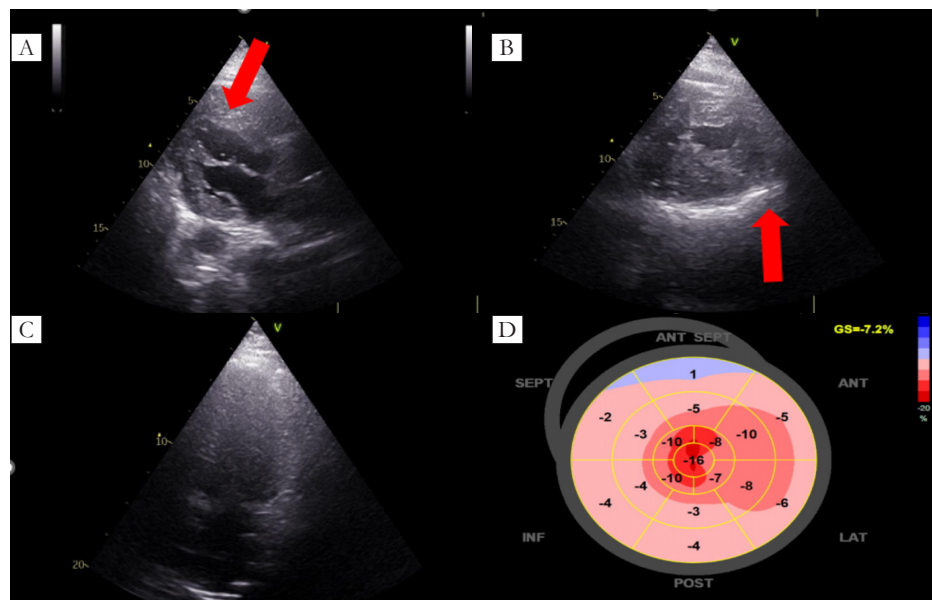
(a) PLAX echocardiography view shows increased myocardial thickness. (b) SAX view shows increased myocardial thickness. (c) A four-chamber view shows increased myocardial thickness. (d) Strain analysis showed an apical-sparing pattern.
